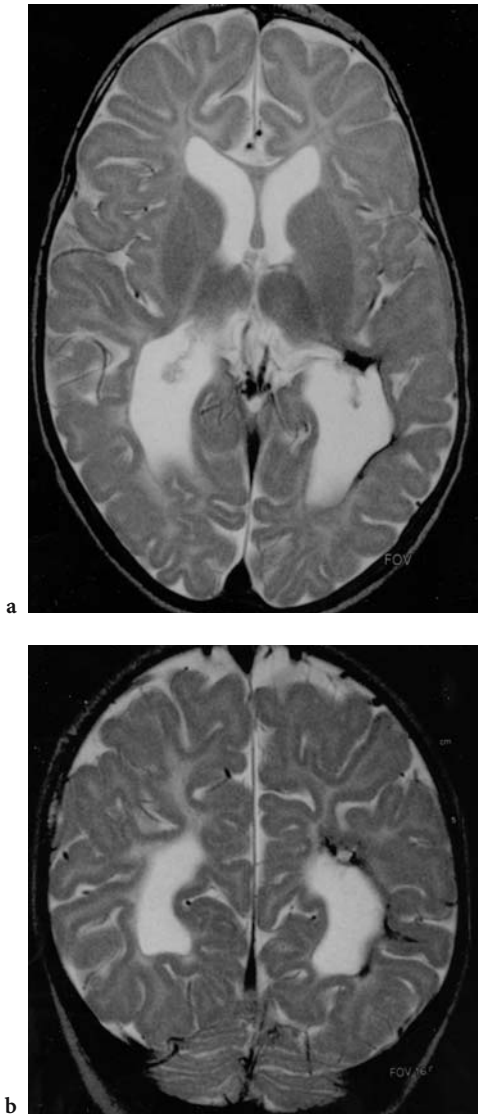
a Axial, b coronal T2-/FSE MRI of an 8-month-old girl who was born prematurely (32 weeks) and subsequently developed tetraspastic cerebral palsy, visual impairment, and infantile spasms. Periventricular leukomalacia is evident: loss of white matter particularly in the posterior parts, irregular ventricular dilatation. There is hemosiderin lateral to the left trigone/posterior horn following periventricular hemorrhage
